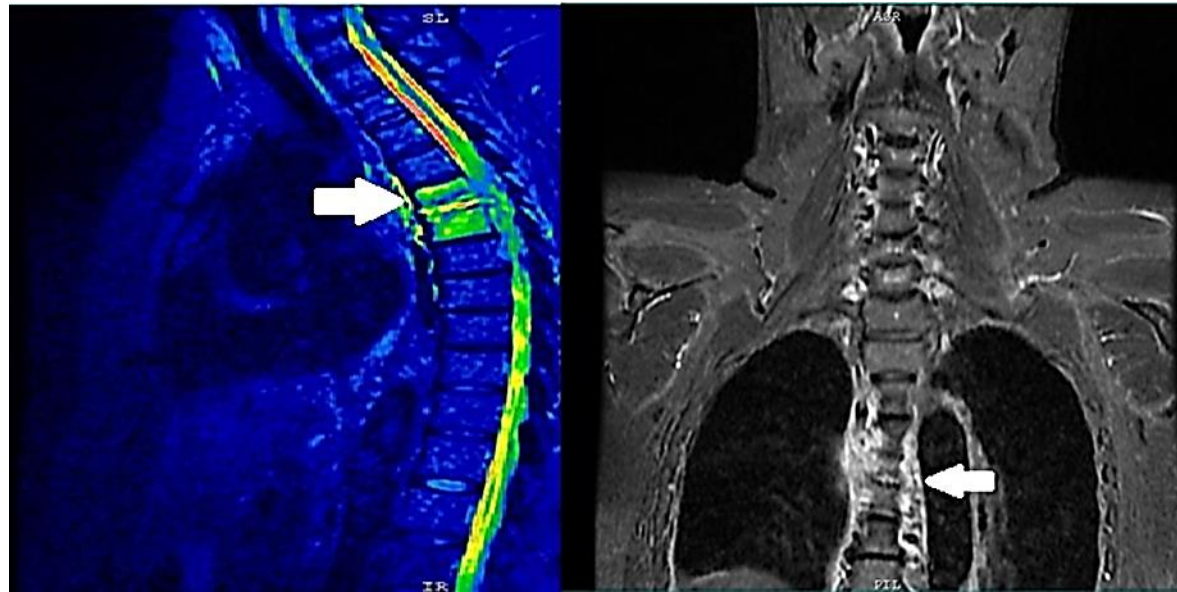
MRI image of the thoracic spine signal changes in the T5 and T6 vertebral bodies and the adjacent disc with enhancing soft tissue components suggesting spondylodiscitis. The solid arrows indicate the affected vertebral bodies and the adjacent discs
